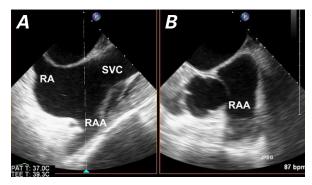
Transesophageal echocardiograms in A) midesophageal bicaval view and B) X-plane image of that view show a right atrial appendage that morphologically resembles a left atrial appendage.
